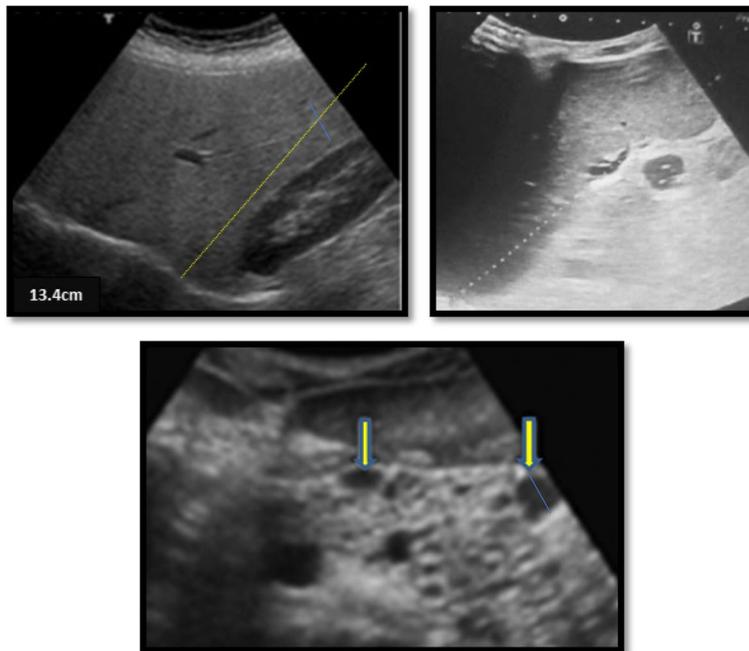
A child known to have cystic fibrosis. He was complaining of chronic cough, vomiting, recurrent abdominal pain, and steatorrhea improving on pancreatic enzyme replacement therapy. His labs are as follows: ALT, 15; AST, 38; Na, 139; K, 4.1; and random blood glucose, 92. Ultrasound of the abdomen shows fatty echogenic liver parenchyma with hepatomegaly measuring about 13.4 cm, splenomegaly measuring 12.9 cm, and increased pancreatic echogenicity with multiple variable-sized cysts measuring up to 20 mm (pancreatic lipomatosis and cystosis, arrow)
